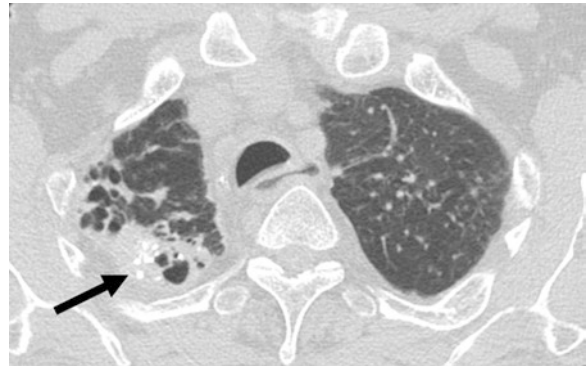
Axial chest CT in a confirmed COVID-19 patient. There are cavitary lesions and foci of parenchymal calcifications in the right lung apex. These lesions are not common in COVID-19 and are likely secondary to underlying pulmonary lesions
